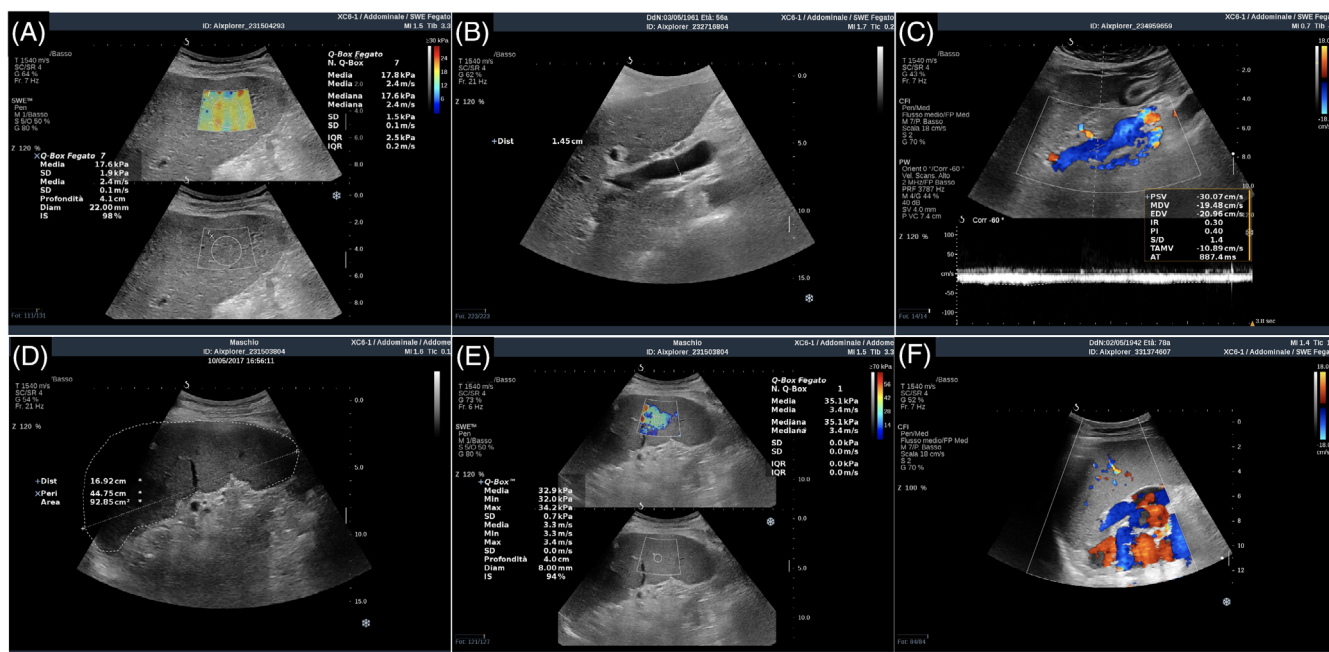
Different ultrasound-based tools for non-invasive evaluation of portal hypertension. (A) 2D shear wave elastography of the liver; (B) portal vein diameter measurement on B-mode; (C) Doppler study of the portal vein; (D) spleen bipolar diameter, perimeter and area evaluated on B-mode; (E) 2D shear wave elastography of the spleen; (F) portosystemic collateral circulation on color Doppler
